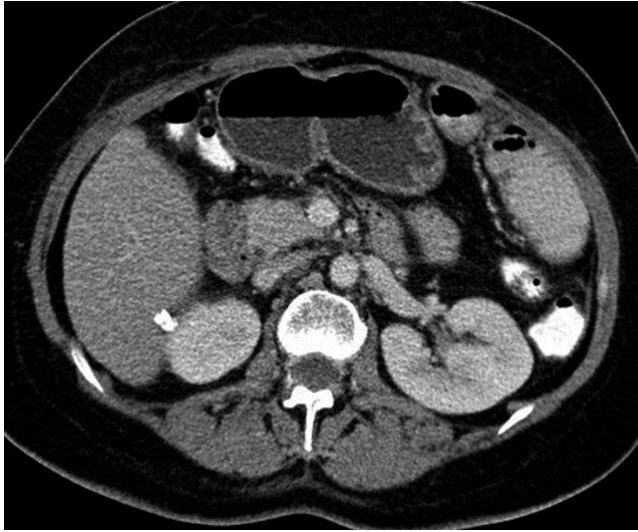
Abdominal CT image. Two hyper dense (*) dropped stones are seen in the hepatorenal space with no evidence of foreign body reaction.
